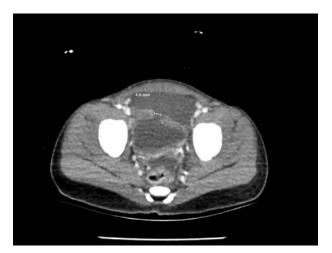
Computed tomography scan of abdomen/pelvis demonstrating anteroinferior bladder wall defect with free intraperitoneal fluid.
